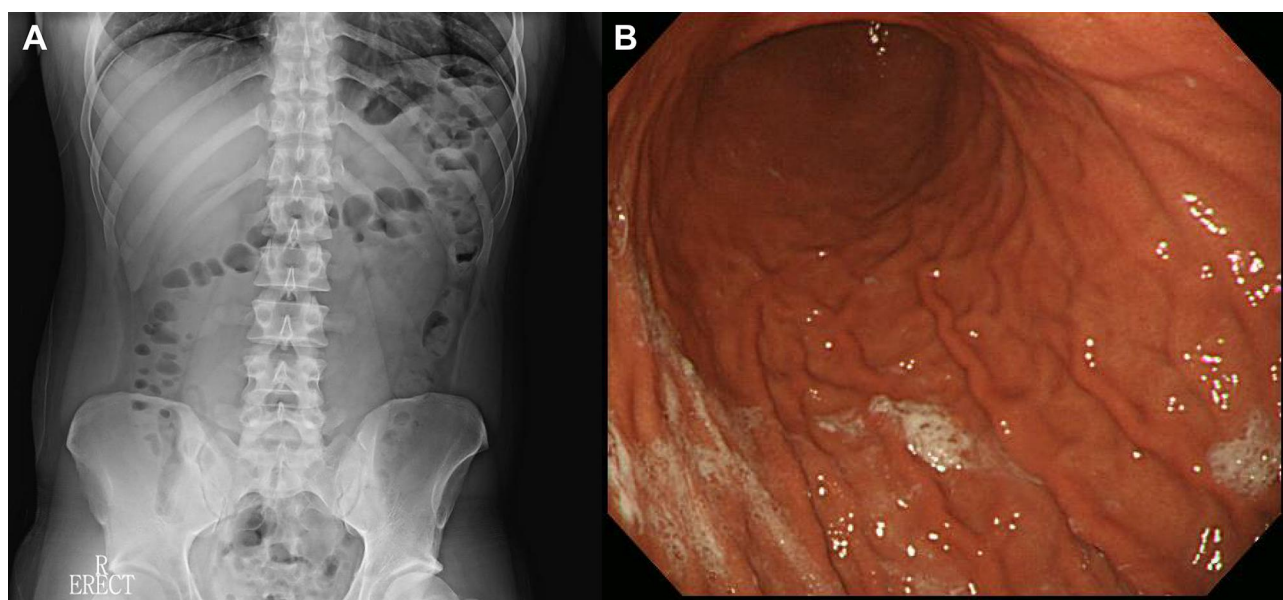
Follow-up plain abdominal radiograph (A) and esophagogastroduodenoscopy (B). The subphrenic free air and hepatic portal venous gas identified in the initial study had almost resolved. Esophagogastroduodenoscopy showed no abnormal findings.
